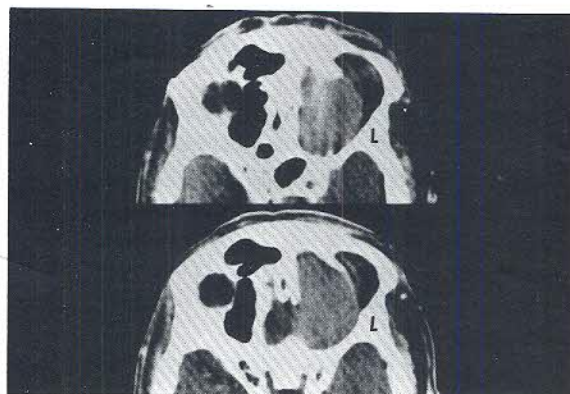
Case 2. CT scan (without contrast) taken preoperatively shows a mucocele involving the ethmoid sinus and extending into the left orbit and nasal cavity.
